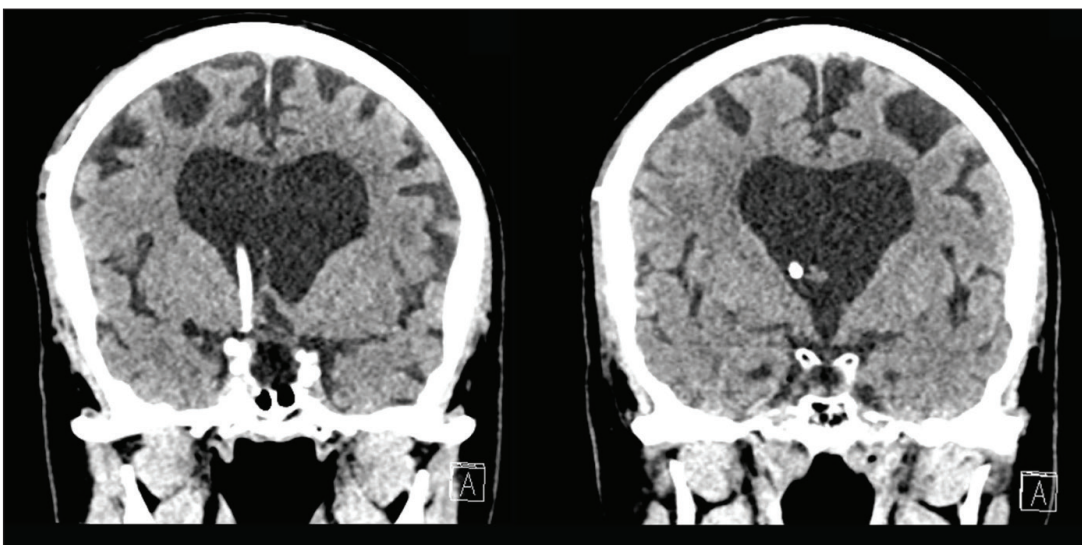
Postoperative coronal computed tomography scans of the patient that underwent early revision surgery due to misplacement of the catheter into the perimesencephalic cistern. Care must be taken during the insertion of catheter even using the neuronavigational device.
